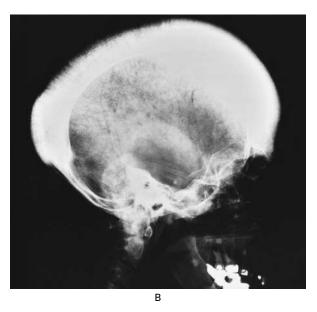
Radiographs of the Chest and Skull in a Patient with Congenital Dyserythropoietic Anemia.
